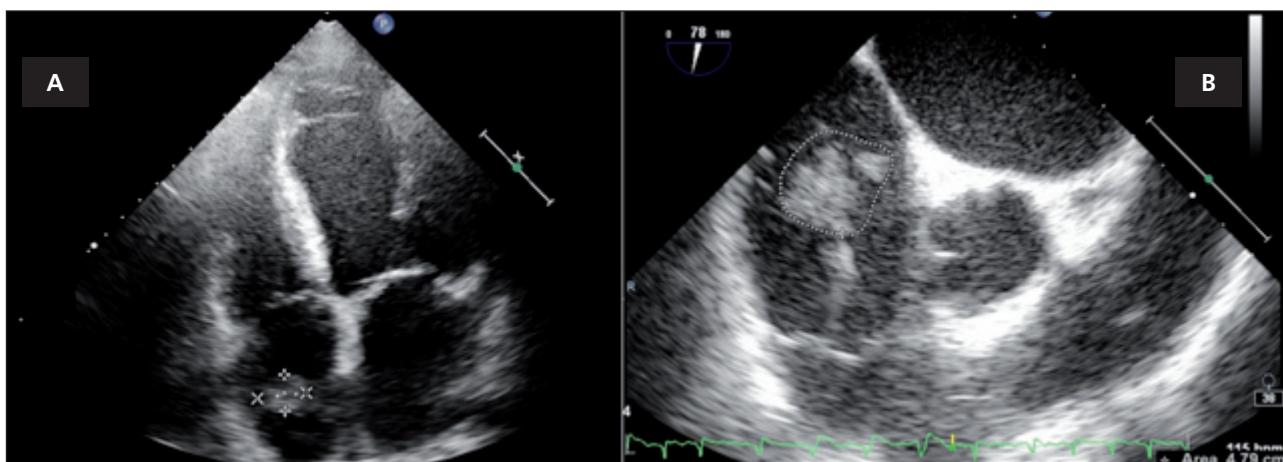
Right atrial thrombus seen in apical 4 chambers at transthoracic echocardiography (A) and at transesophageal echocardiography (B) at first presentation.
